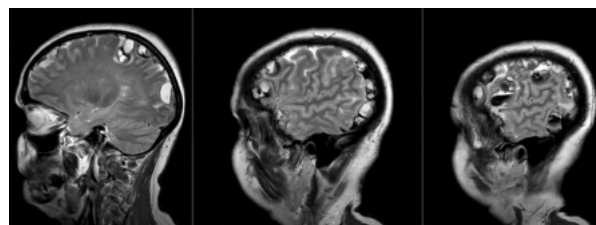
Case 2: Sagittal T2 weighted MR images showing extensive locules of subdural haemorrhage along the left concavity with evidence of blood layering within them and spillage into the subarachnoid space
